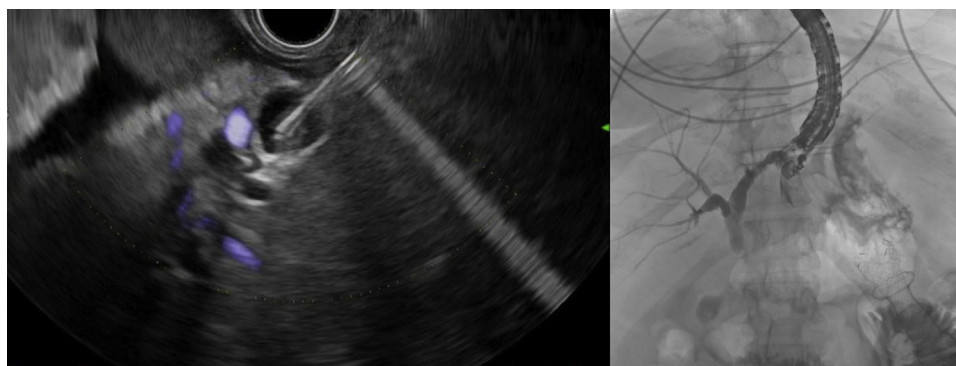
Endosonographic and fluoroscopic image demonstrating puncture of dilated left intrahepatic duct to create hepaticogastrostomy and antegrade cholangiogram.
